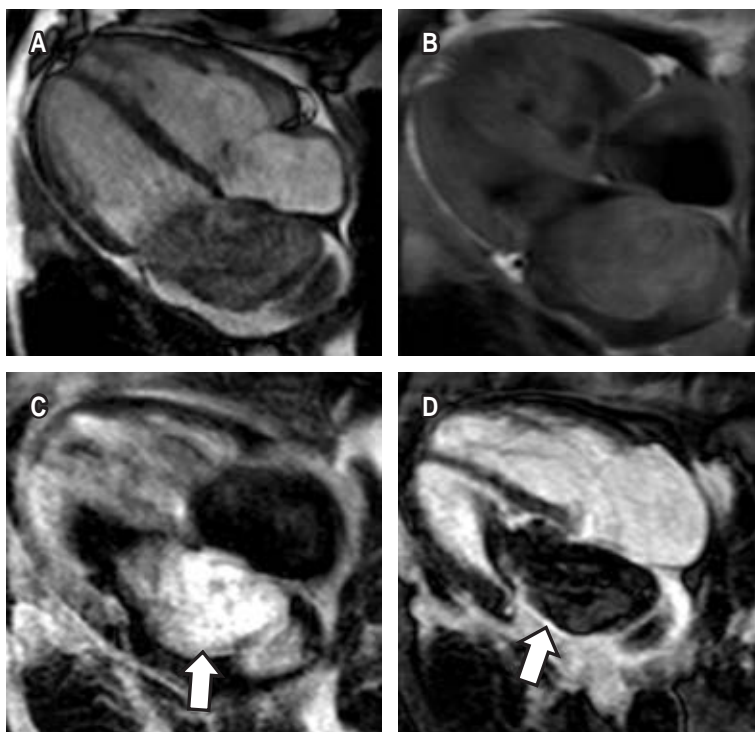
Cardiac magnetic resonance imaging showing left atrial mass. A) Cine (SSFP) four chambers. B) T1 FSE I-R four chambers. C) STIR T2W FSE I-R four chambers showing hyperintense mass suggesting high fluid content. D) T1 GRE I-R (late enhancement). White arrows point to hyperintense mass and areas of late enhancement in C and D, respectively.
